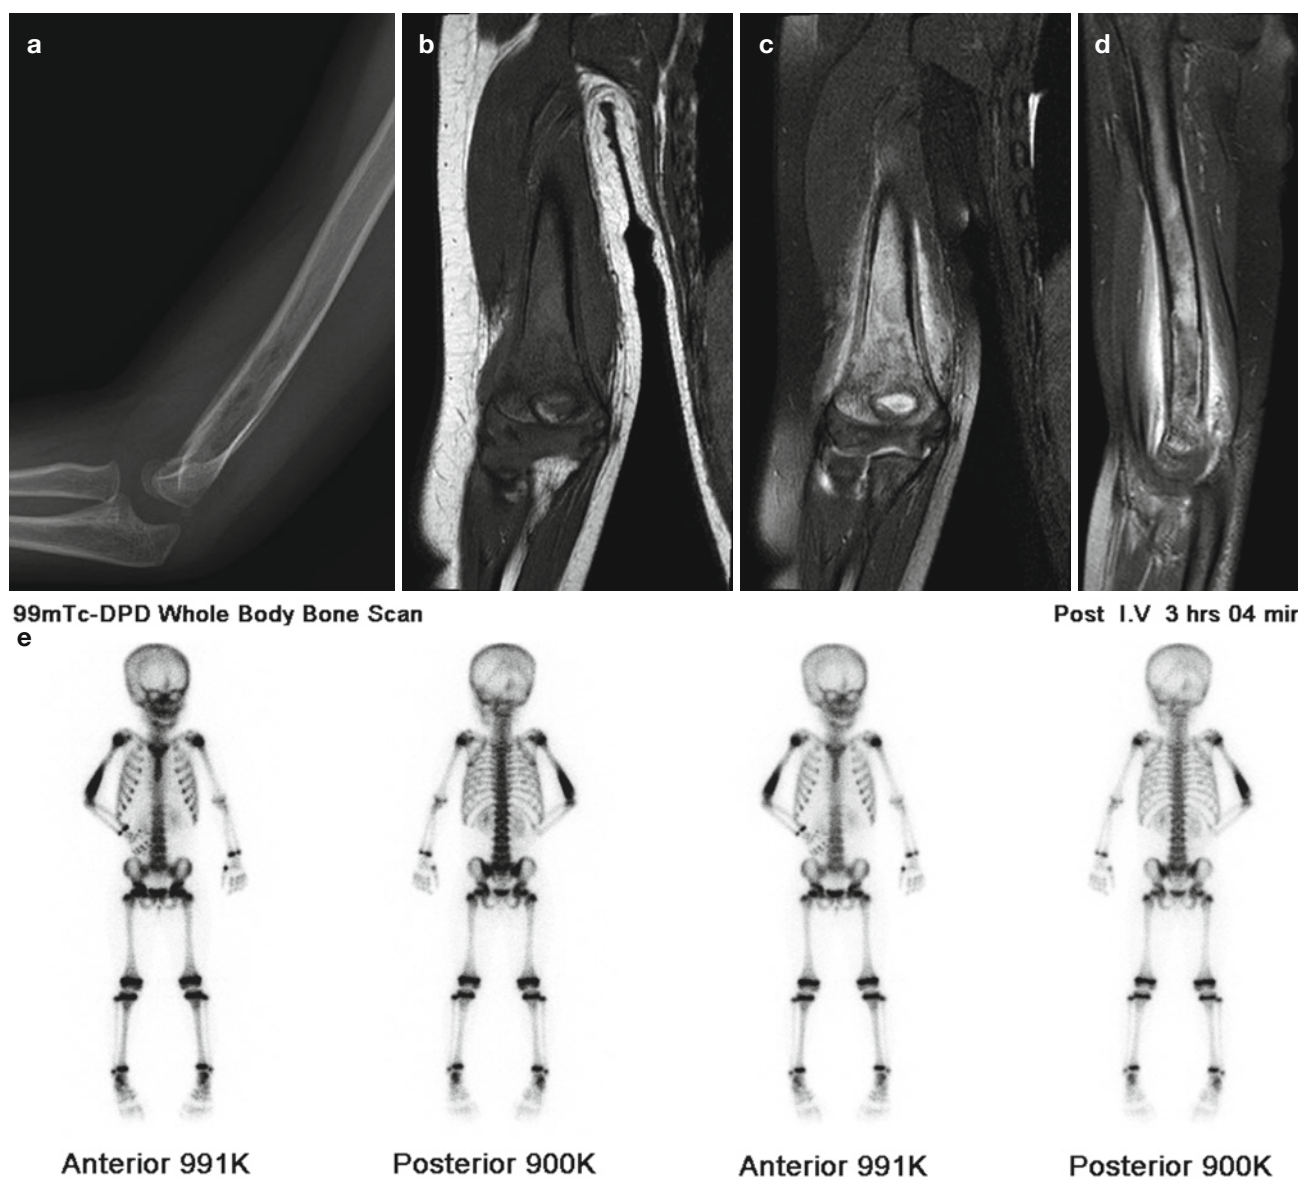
Langerhans cell histiocytosis in a 3-year-old boy.* (a) Humerus lateral radiograph shows an ill-defined radiolucent bony lesion with a moth-eaten or permeative appearance involving the meta-diaphyses with lamellated periosteal reaction. (b–d) MR T1-weighted image (b) shows abnormal marrow replaced by low signal intensity in the distal humerus metadiaphysis which is a hyperintense bony lesion on fat-suppressed T2-weighted image (c). Bone and surrounding soft
